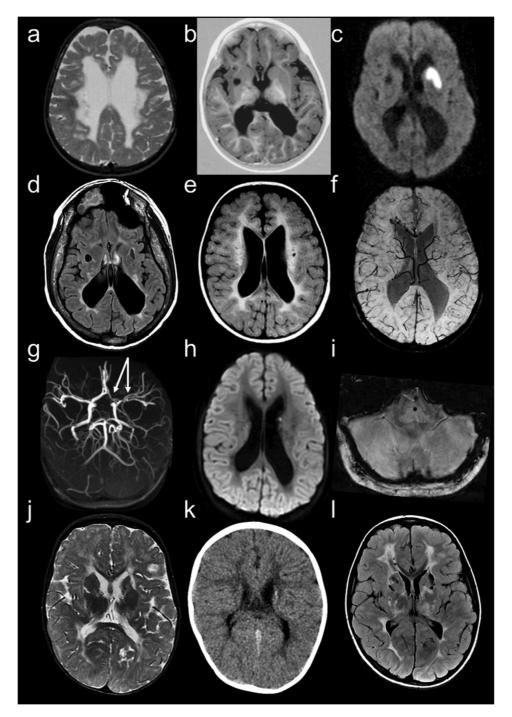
MRI scans of patient 1. (a, b) The first MRI, at age 1 year and 7 months, shows extensive white matter signal abnormalities, a lacune in the right putamen, white matter atrophy, and a thin corpus callosum. (c) At the age of 5 years, a recent ischemic stroke is detected by restricted diffusion (DWI, b1000) with a low ADC (not shown) in the left putamen. (d) The last MRI scan at age 22 years shows severe white matter volume loss and extensive signal abnormalities of what is left of the white matter, sparing the directly subcortical white matter, as well as bilateral lacunes in the putamen. MRI scans of patient 2. (e) The first MRI at age 13 months shows mildly dilated lateral ventricles and extensive white matter signal abnormalities. (f) At age 2 years and 7 months, hemosiderin depositions along the right genu corpus callosum are seen. (g) MR angiography at 3 years and 3 months showed a hypoplastic left middle cerebral artery (M1- and M2-segment) and a hypoplastic left anterior cerebral artery (A1-segment); the hypoplastic areas are marked by arrows. (h, i) The MRI at age 7 years shows a punctate lesion with restricted diffusion in the left caudate nucleus and a microbleed at the pontomedullary junction. (j-l) Neuroimaging of patient 3. (j) The first MRI, at 1 year, shows signal abnormalities in the cerebral white matter and basal ganglia with reduced volume of both. (k) 7 months later, CT shows subtle hyperdensities adjacent to the left ventricle, indicative of calcium deposits. (I) The latest MRI, at 6 years, shows bilateral lacunes in the basal ganglia.
